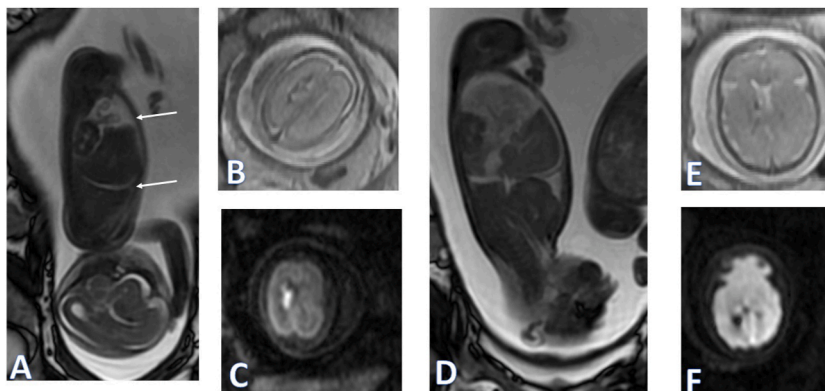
A 25-GW TTTS stage 1 fetus in monochorionic twin pregnancy. One fetus had bleeding components (A) in the lateral ventricle on FIESTA images. Note that pleural effusion and ascites are shown (arrow). The band of the low signal in the adjacent parenchyma was also detected on the SS FSE image (B) and DWI (C). On three-week follow-up MR (D–F), both pleural effusion and ascites continued to grow (D). The hemorrhage components in the ventricle seemed to be resolved to some extent (E/F). However, subsequent US did not detect a fetal heartbeat and confirmed in-utero fetal death. The other fetus (not shown) was delivered at 31 GW (birth weight: 1205 g, 1 min Apgar score: 9).
